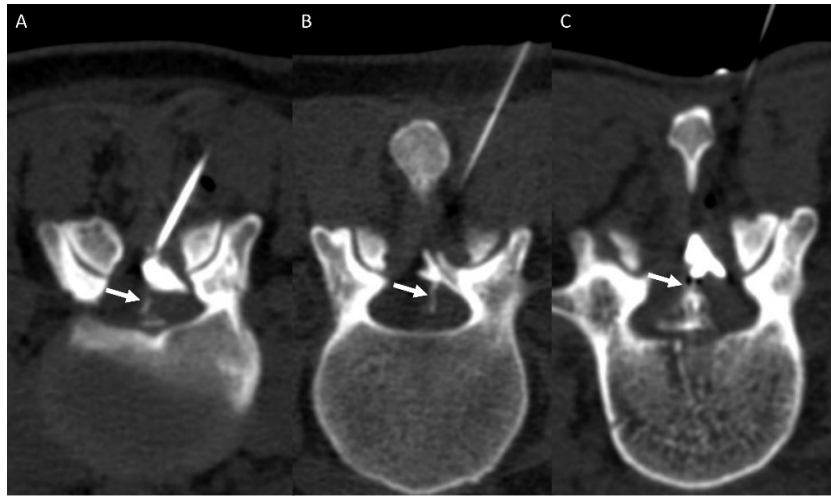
Three additional patients who had contrast jets (arrows) seen during CT guided injection of contrast into the epidural space, signifying a persistent dorsal dural defect.
